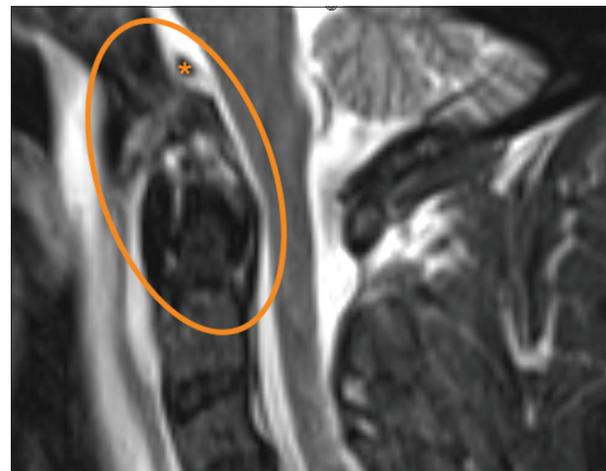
Magnetic resonance imaging cervical spine (mid-sagittal view) shows signs of injury to the ligamentous complex at the craniocervical junction (oval figure). It also shows a focal tear in the tectorial membrane (asterisk).
